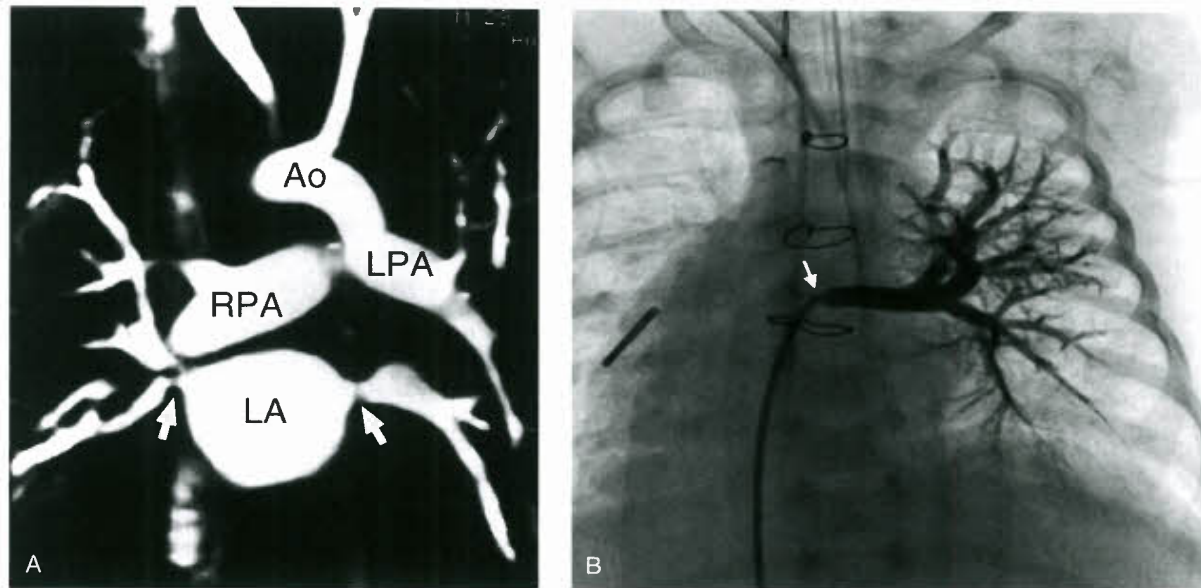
Pulmonary vein stenosis. A: Maximal-intensity projection image from a gadolinium-enhanced 3-D magnetic resonance angiogram (MRA) in a 21-year-old man with severe bilateral pulmonary vein stenoses (arrow). The patient was referred for MRI examination to rule out constrictive pericardial process after an evaluation by echocardiography and cardiac catheterization at another institution did not find a cause for the patient's severe pulmonary hypertension. The MRI findings were subsequently confirmed at cardiac catheterization in which balloon dilations of the pulmonary veins stenoses were performed. B: Catheter angiogram in a 3-month-old infant with heterotaxy syndrome, dextrocardia, and supracardiac TAPVC that had been repaired with anastomosis of the pulmonary venous confluence to the posterior aspect of the common atrium. Angiogram with catheter in the left upper pulmonary vein (LUPV) demonstrates the severe, discrete narrowing of the LUPV at the junction with the pulmonary venous confluence (arrow), with narrowing to the diameter of the catheter (1.2 mm). Note the lack of involvement of the proximal LUPV in the obstruction.
